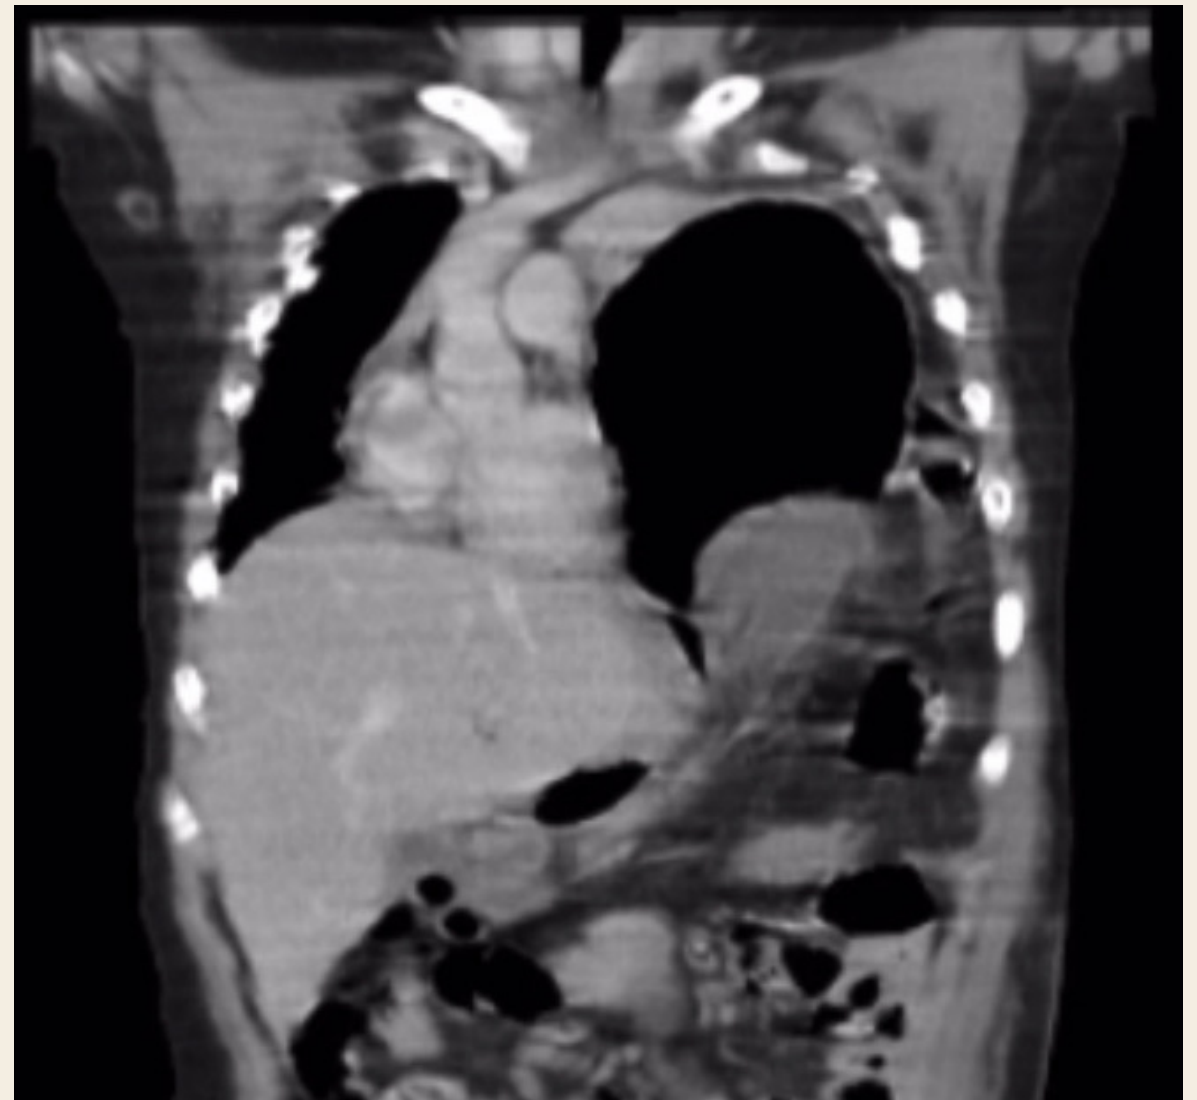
Computed tomography showing mediastinal displacement and transdiaphragmatic abdominal visceral herniation.
